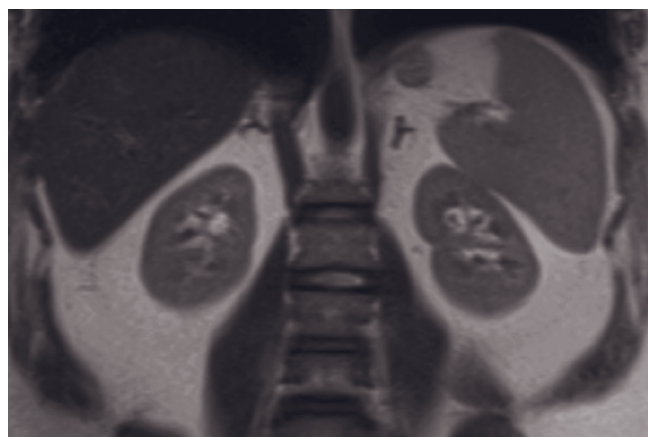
(Continued) fat-suppressed 3D-GE (n), T1-weighted postgadolinium hepatic arterial dominant-phase (o), and interstitial-phase (p) fat-suppressed 3D-GE images demonstrate the normal right adrenal gland in another patient. Note the capillary blush in the right adrenal gland. T1-weighted SGE (q), T1-weighted fat-suppressed 3D-GE (r), T1-weighted postgadolinium hepatic arterial
